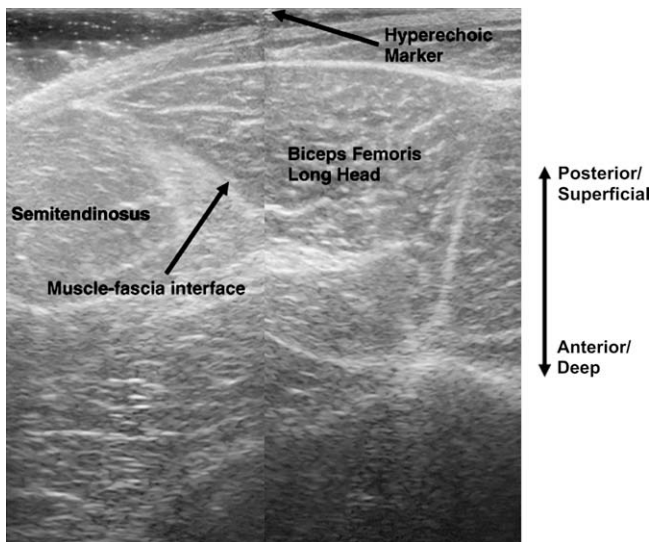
Axial plane ultrasound image of the biceps femoris long head captured at the midpoint of the thigh. The hyperechoic marker can be seen in the top left corner of the image on the right. Image depth is 8 cm.
